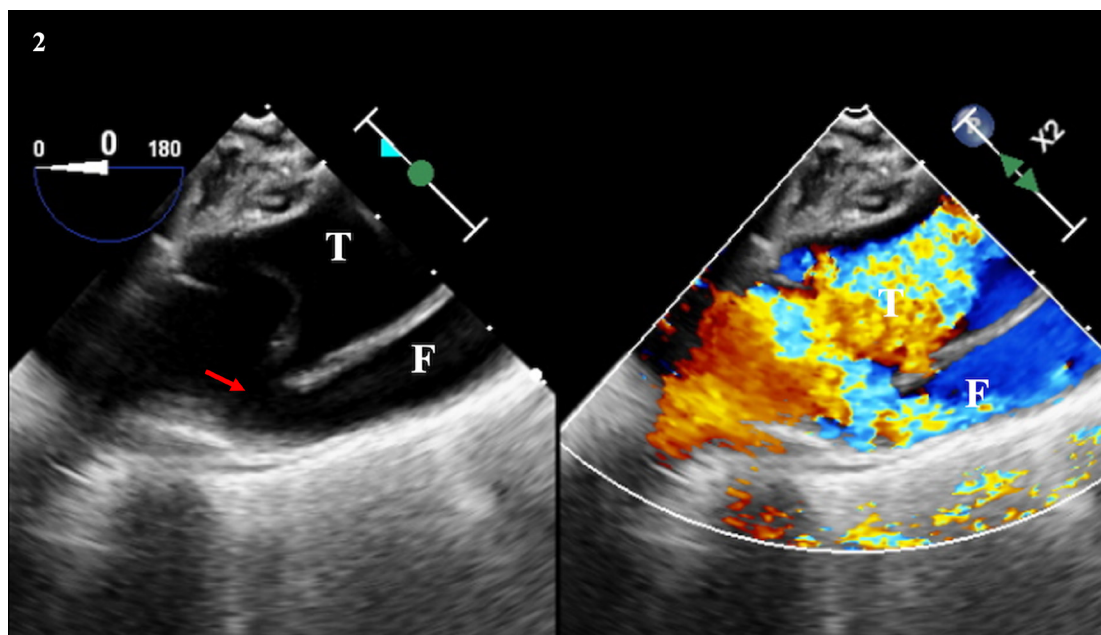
Intraoperative transesophageal echocardiography showing an aortic dissection from the distal anastomosis site. The red arrow shows the entry site. The blood flow in the false lumen is shown. F, false lumen, T, true lumen
